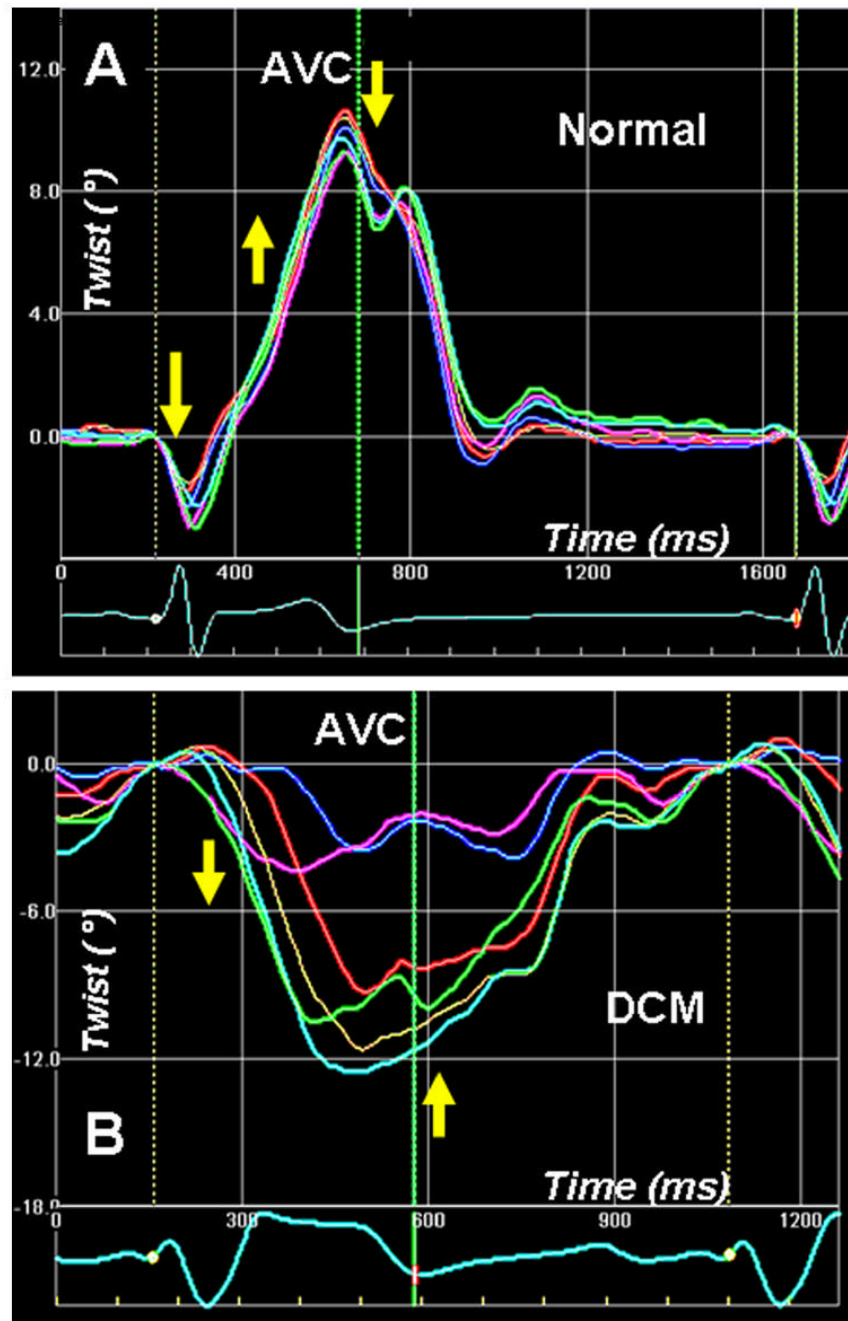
Left ventricular apex rotation (twist) measured by 2-D speckle tracking of B-mode ultrasound images (2D strain) in a normal individual (A). An initial clockwise rotation occurs during the preejection period, followed by counterclockwise twisting during the ejection phase. Clockwise untwisting occurs predominantly during the phase of isovolumic relaxation. The adjoining panel (B) shows apical twist in a patient with dilated cardiomyopathy with dysfunctional apex. The apical twist sequence is completely the reverse of normal, i.e. apex rotates in clockwise direction during ejection, and in counterclockwise direction in diastole. Phases 1–5 are described in Fig. 3 legend.
